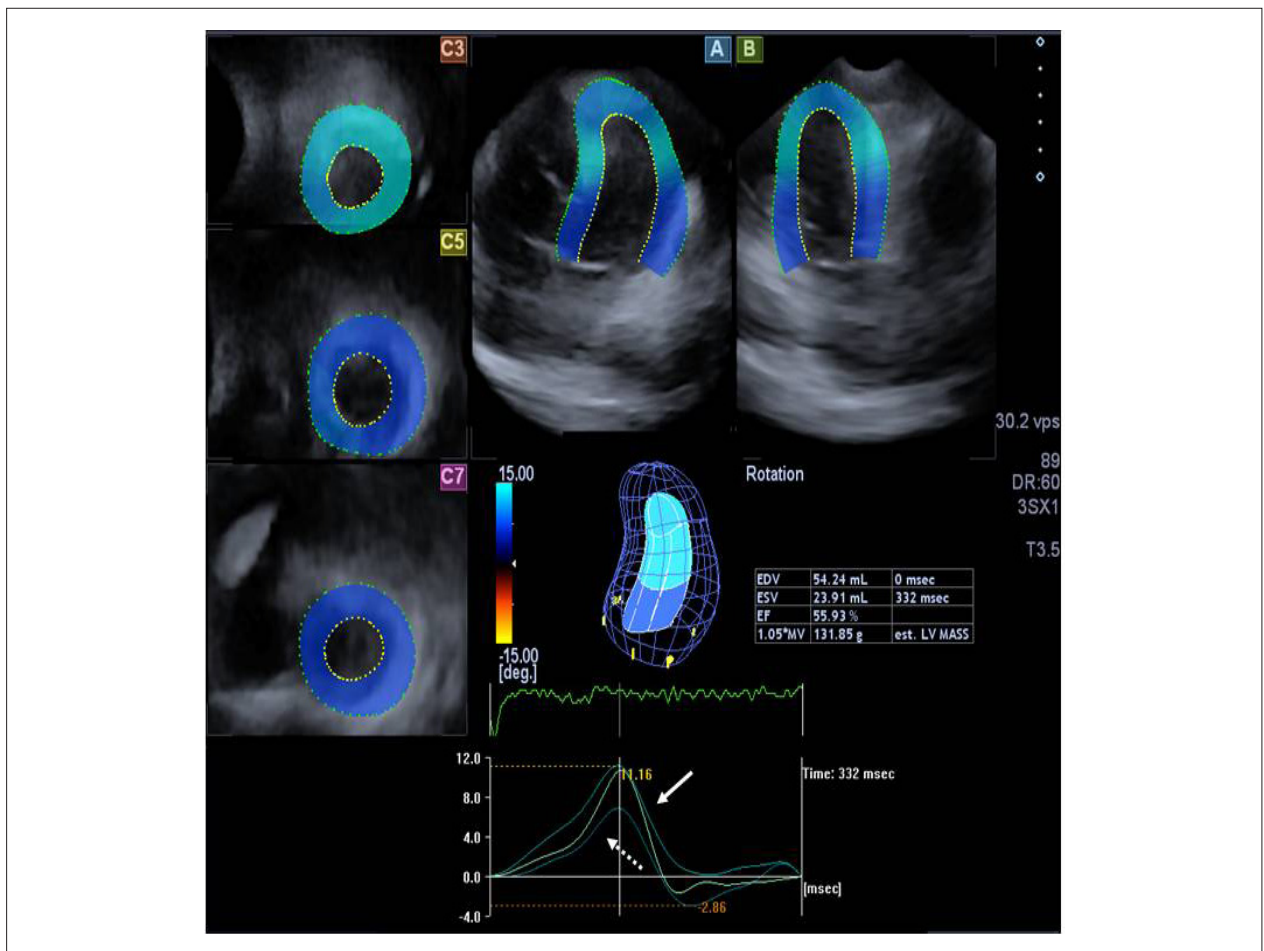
Apical 4-chamber (A) and 2-chamber (B) views and short-axis views (C3, C5, C7) at different levels of the left ventricle (LV) extracted from the three-dimensional (3D) echocardiographic dataset are shown in the patient with Ebstein's anomaly. The 3D image of the LV and calculated LV volumetric and functional characteristics (EDV: end-diastolic volume; ESV: end-systolic volume; EF: ejection fraction) are also demonstrated together with LV apical (white arrow), mid-ventricular and basal (dashed arrow) rotations in the same counterclockwise direction, confirming absence of the LV twist, called "rigid body rotation".
